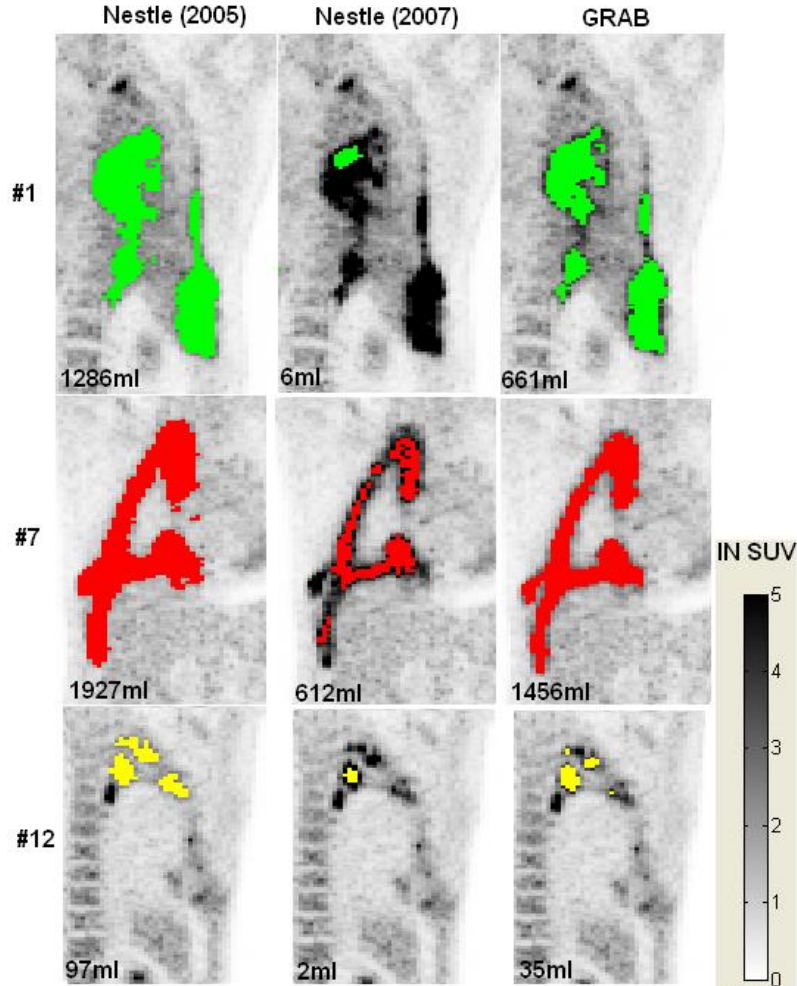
Segmentation Methods using Background and SUV_{mean}
